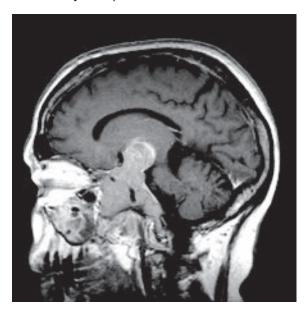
MRI of the brain sagittal view shows vertical extension of pituitary macroadenoma compressing the third ventricle and corpus callosum.
